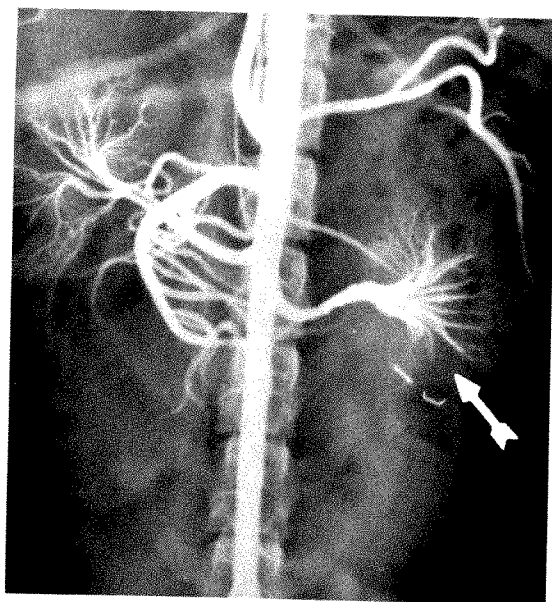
Case v. Roentgenogram made in arterial phase following separation of lower pole of the left kidney and then replacement of lower pole by resuturing capsule. Note loss of vessel branches.
